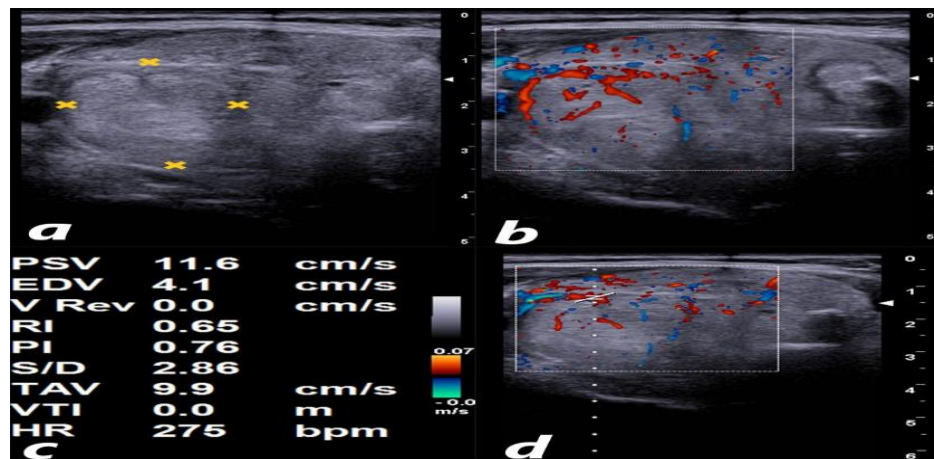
(a) Grey scale image of right lobe of thyroid gland showing a hyperechoic solid nodule (yellow cursors). (b) Color Doppler image of the same nodule showing intense peripheral and mild internal vascularity. (c & d) Duplex Doppler image showing the RI of 0.65 (consistent with the benign nodule).
